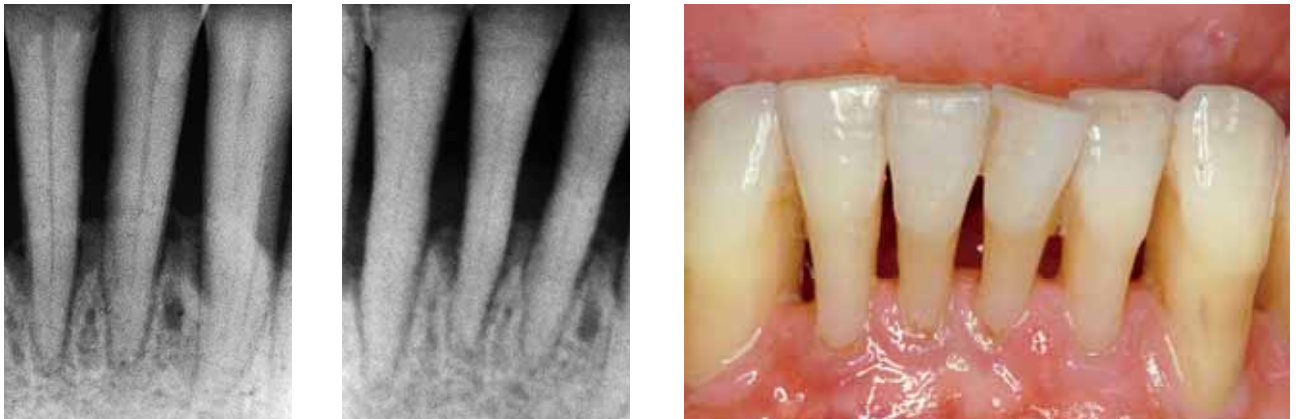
to c On a long-term basis, it is possible to conserve critical mandibular anterior teeth even in the case of severely advanced horizontal bone loss (a). The radiograph (b) shows no clinically relevant bone loss after 10 years. The patient cleans his teeth with interdental brushes that fill out the spaces (c). In this case the teeth were not splinted.
